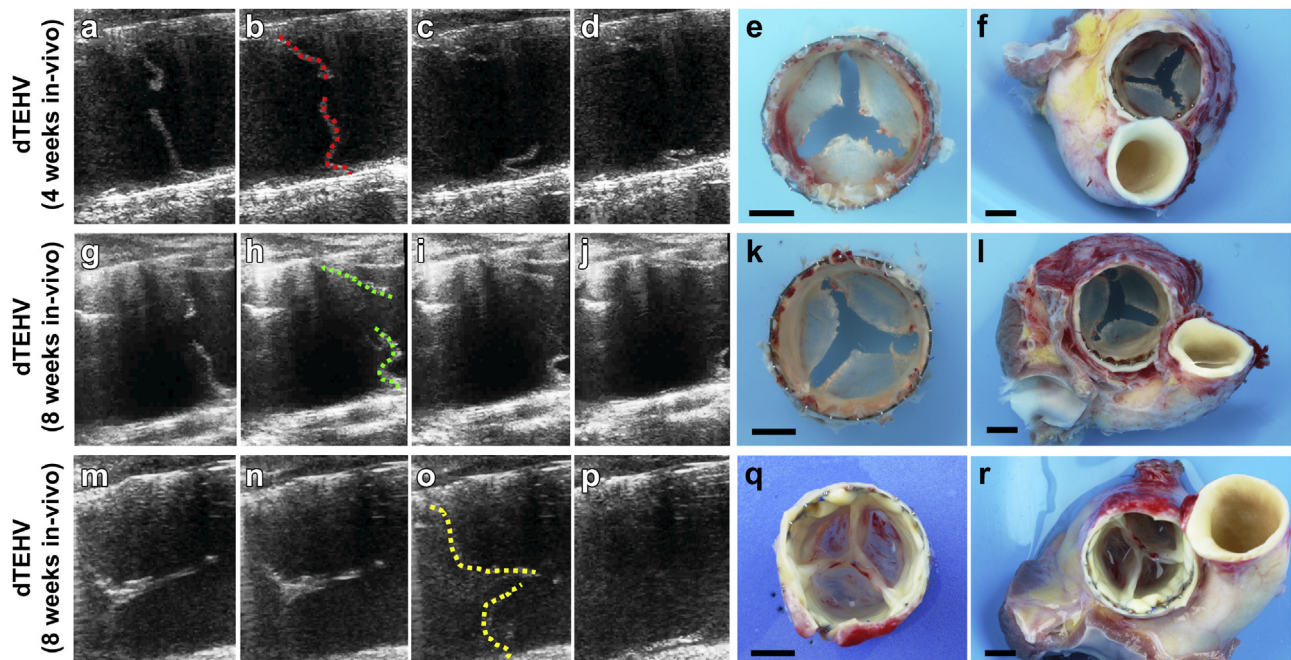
Functionality and macroscopic outcome of the valves. Decellularized tissue-engineered heart valves (dTEHVs) showed mobile and pliable cusp-like leaflet structures by echocardiography 4 weeks after implantation (a–d). As the leaflets were shortened in the radial direction (a, and indicated by the red lines in b) coaptation was lacking. The 4 week explants (e–f) confirmed the reduced leaflet size, but leaflet tissue was thin, shiny and without signs of thrombotic depositions. After 8 weeks follow-up, the dTEHVs demonstrated similar echocardiographic (g–j) and macroscopic results (k–l) without further reduction of the leaflet size. The dHNV showed in-vivo functionality and ex-vivo leaflet geometry comparable to clinically used xeno- or allogenic transplants (m–r). (For interpretation of the references to color in this figure legend, the reader is referred to the web version of this article.)
